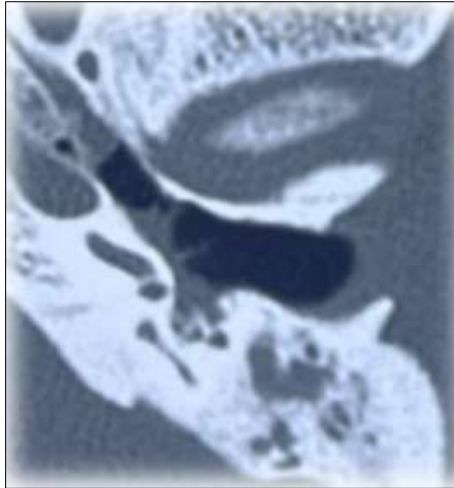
Preoperative CT image showing the filling of the tympanic sinus
